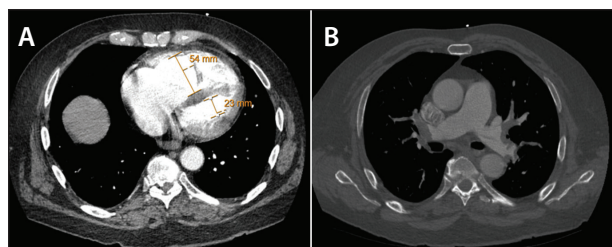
CT scan showing RV/LV ratio of 2.3 (A). Bilateral clot burden partially imaged (B).
